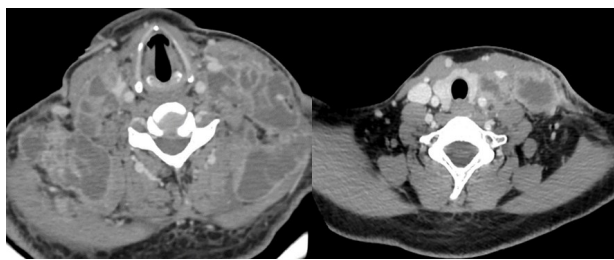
Representative CT images of (A) a cervical lymph node tuberculosis patient with AIDS and (B) a cervical lymph node tuberculosis patient without AIDS.
